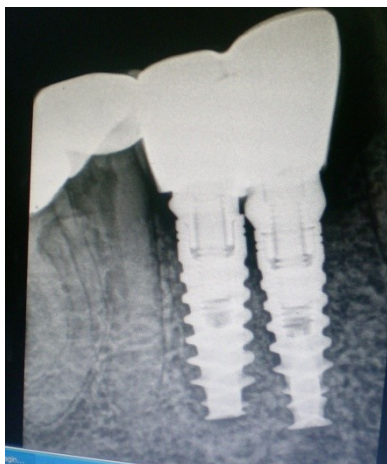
Radiograph verifying the fit of the abutment
